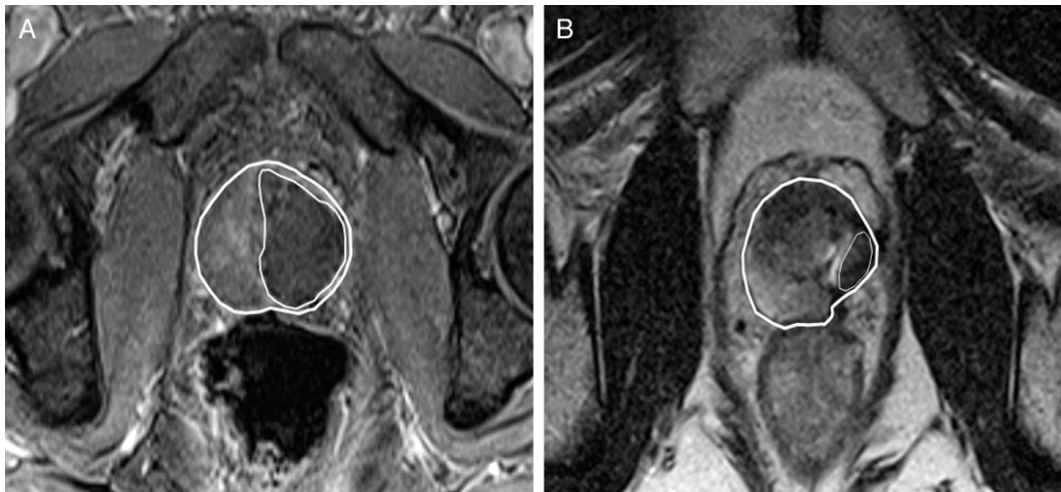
Axial contrast enhanced MRI demonstrating area of poor perfusion in left hemi-prostate 2 weeks after left HIFU hemiablation (A), and axial T2-weighted MRI demonstrating treated area on left has reduced in size at 6 months leaving 0.9 ml residual tissue (B).
